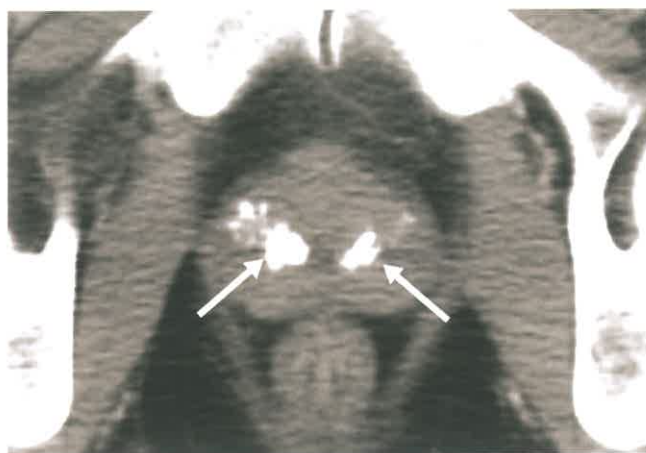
Prostate Calcifications. Axial postcontrast CT shows a mildly enlarged prostate with prominent coarse calcifications (arrows) typical of calcification associated with benign prostate hypertrophy.
